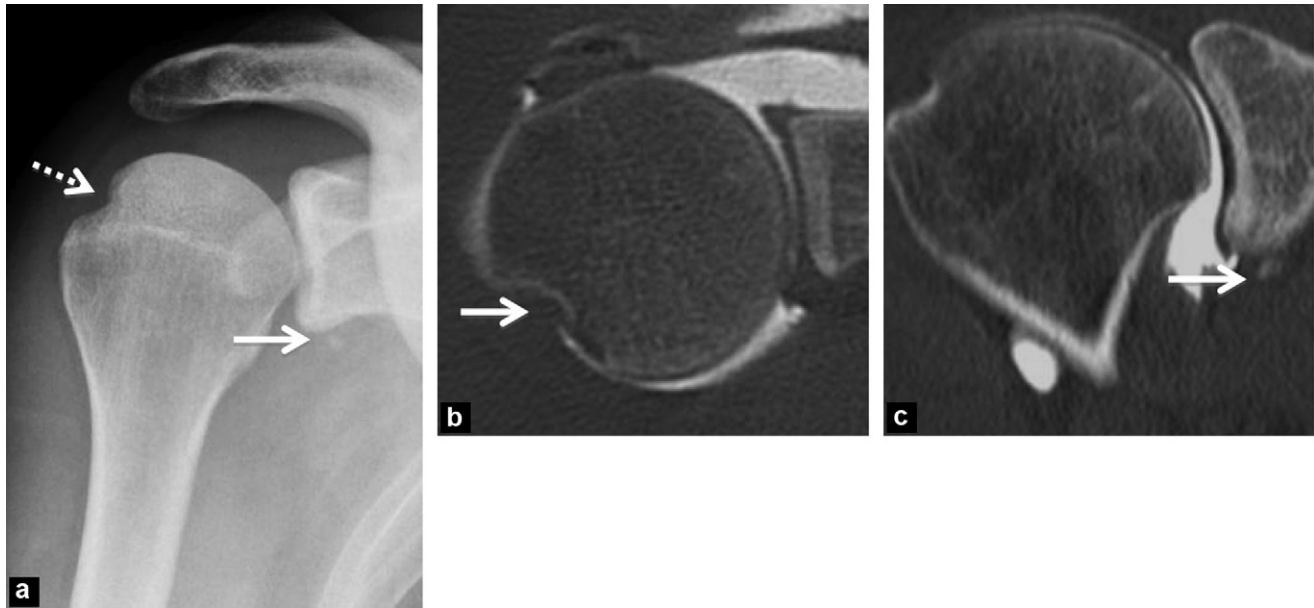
Anterior-internal dislocation of the shoulder. a: standard X-ray (front internal rotation): Maigne notch (dotted arrow) and bone tear at the lower edge of the glenoid (full arrow); b and c: the CT arthrogram (axial [b] and coronal reformats [c]) confirms the lesions.
